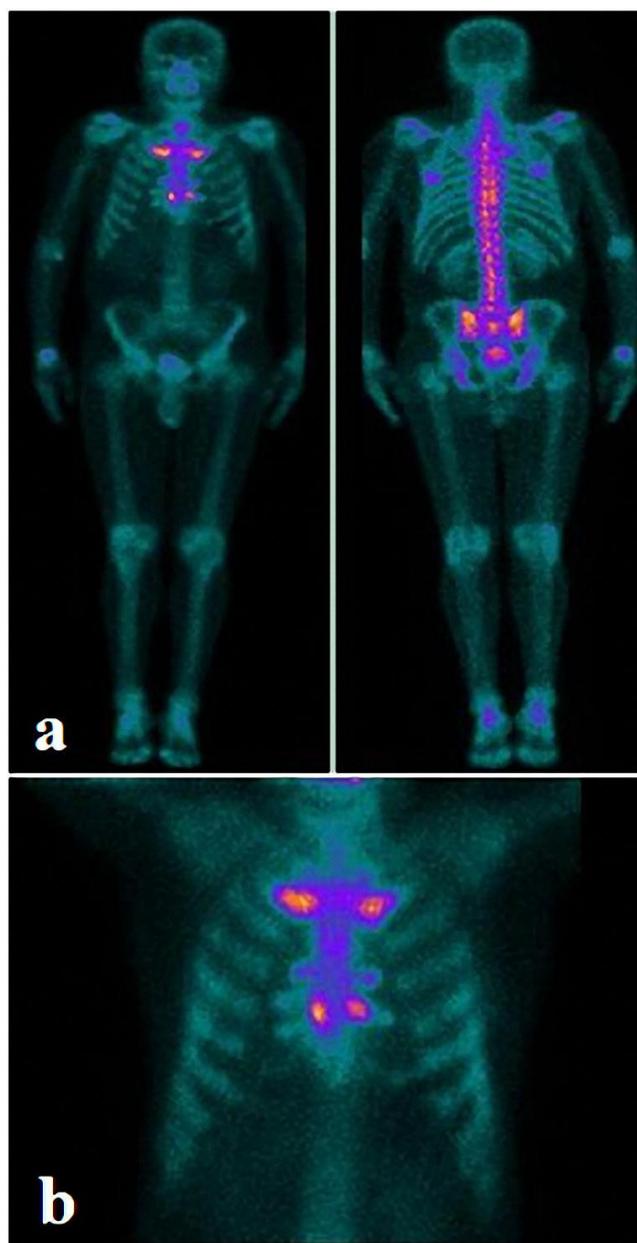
Late whole body (A) and static (B) bone scintigraphy images, markedly increased activity accumulation in first sternocostal junction, increased activity accumulation in 3rd, 4th and 5th sternocostal junctions and lateral portion of inferior part of corpus sterni is seen.
